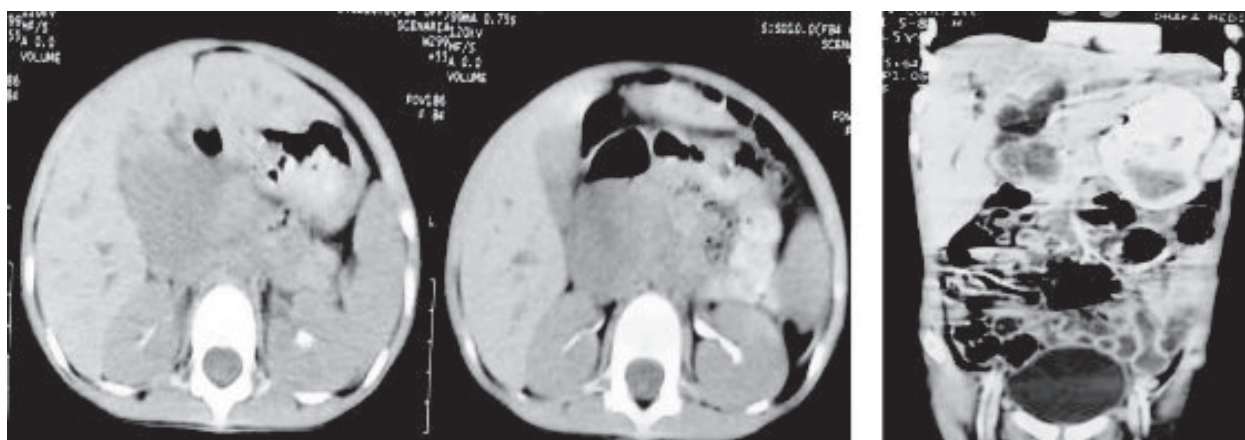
Post contrast axial & coronal images of CT scan showing a large mass in hepatic duct confluence.*
